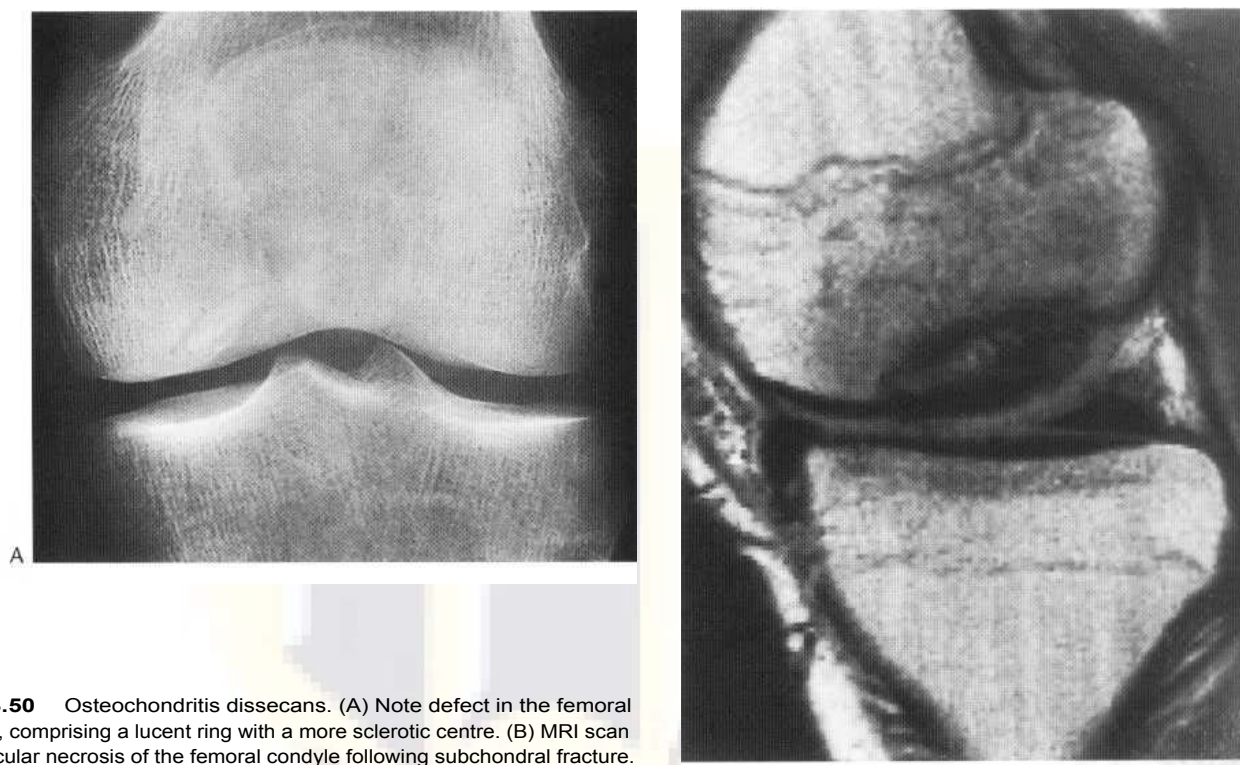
Osteochondritis dissecans. (A) Note defect in the femoral condyle, comprising a lucent ring with a more sclerotic centre. (B) MRI scan of avascular necrosis of the femoral condyle following subchondral fracture.
